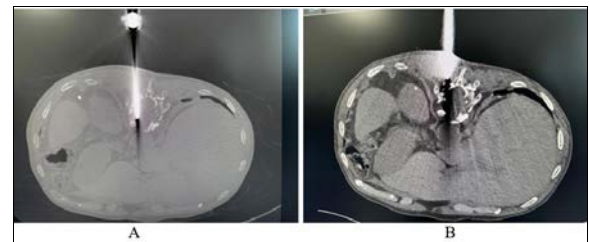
CT guided biopsy of lytic vertebral lesion approached through transpedicular route in prone position (bone and soft tissue window settings). 11G Jamshidi bone biopsy needle was used.
